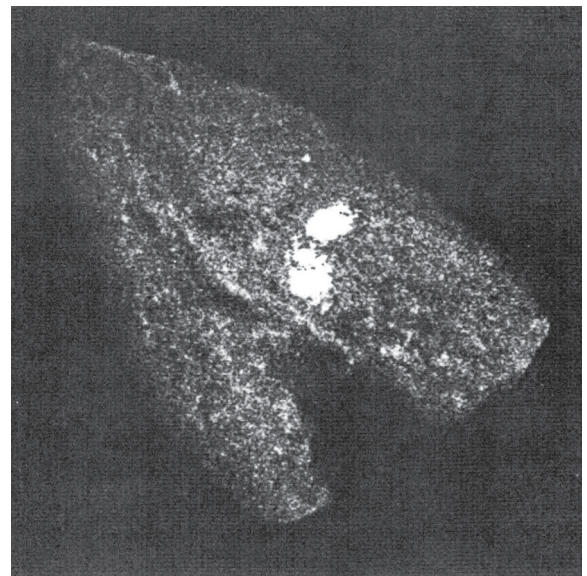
X-ray of the loaf from Ovelgönne. Dr. H. Cames, Bern, who performed the X-ray, considers that the two light spots are metal pieces. From Währen (1995, 213).
